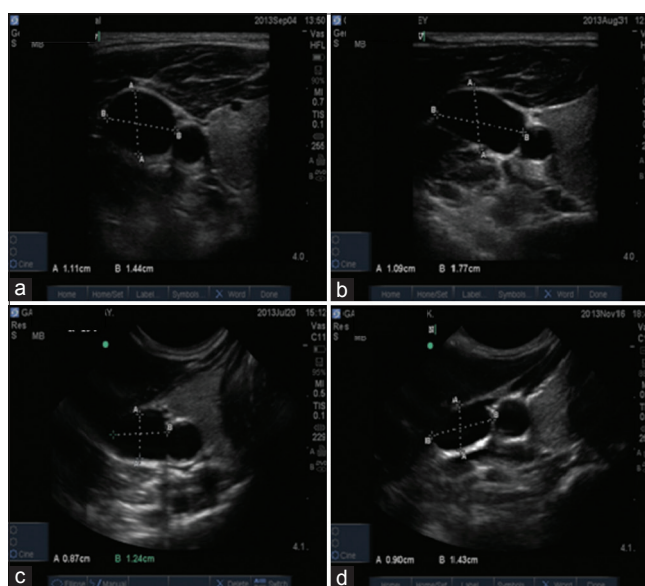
Ultrasonography images of internal jugular vein relation to common carotid artery. (a) Antero-lateral to Artery, Segment 1. (b) Antero-lateral to Artery, Segment 2. (c) Lateral to Artery, Segment 3. (d) Postero-lateral to Artery, Segment 4
